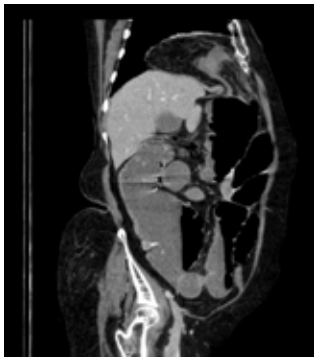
CT image showing obstructed retrosternal Hernia with dilated bowel loops.
